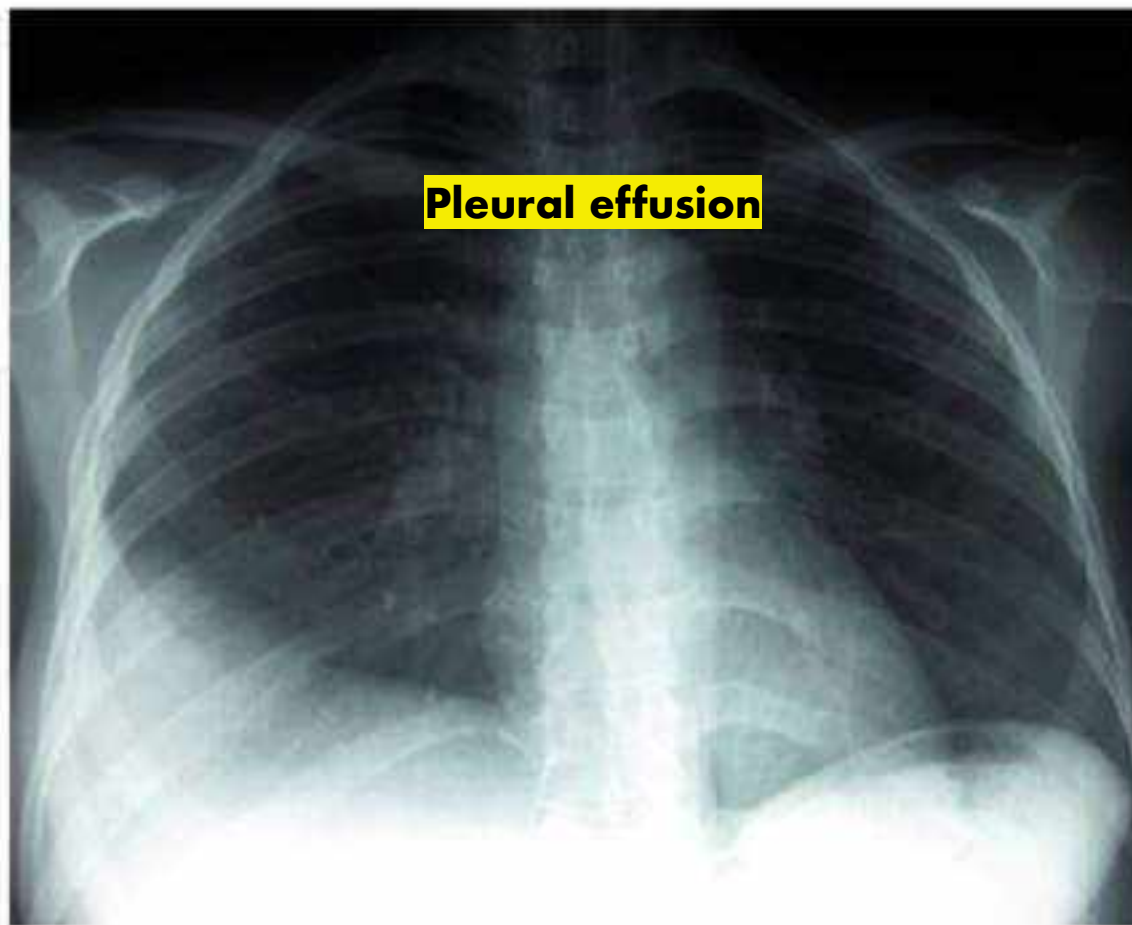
Chest radiograph showing a right pleural effusion with atelectasis
